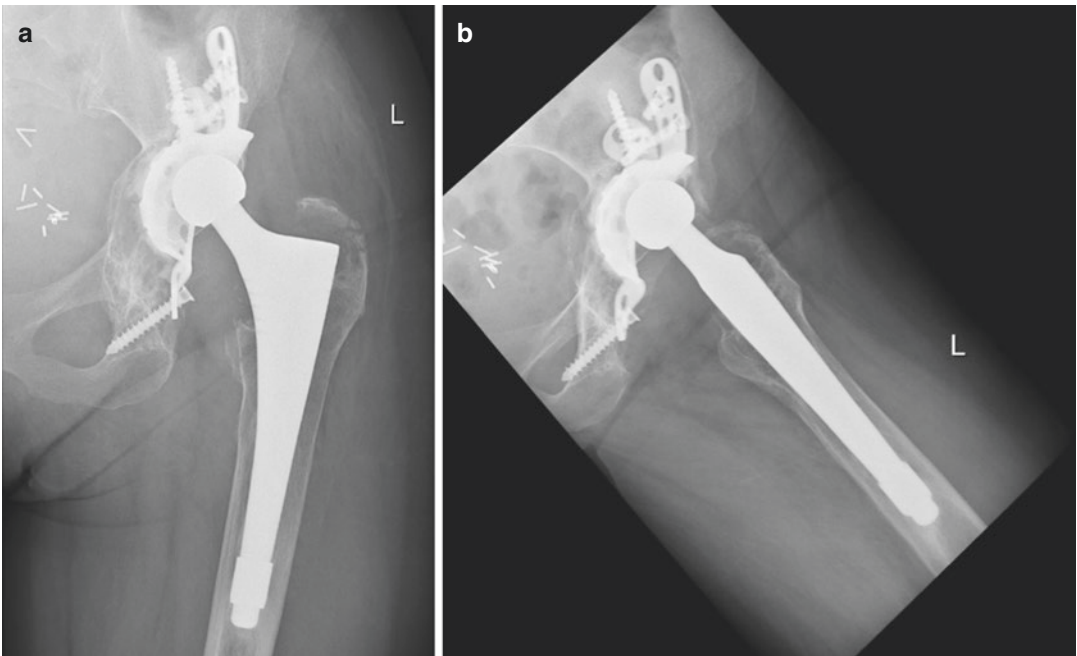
(a, b) AP pelvis and frog lateral left-hip radiographs taken on initial presentation, demonstrating severe polyethylene wear, evidence of revision acetabular component loosening, and superior migration of the femoral head
